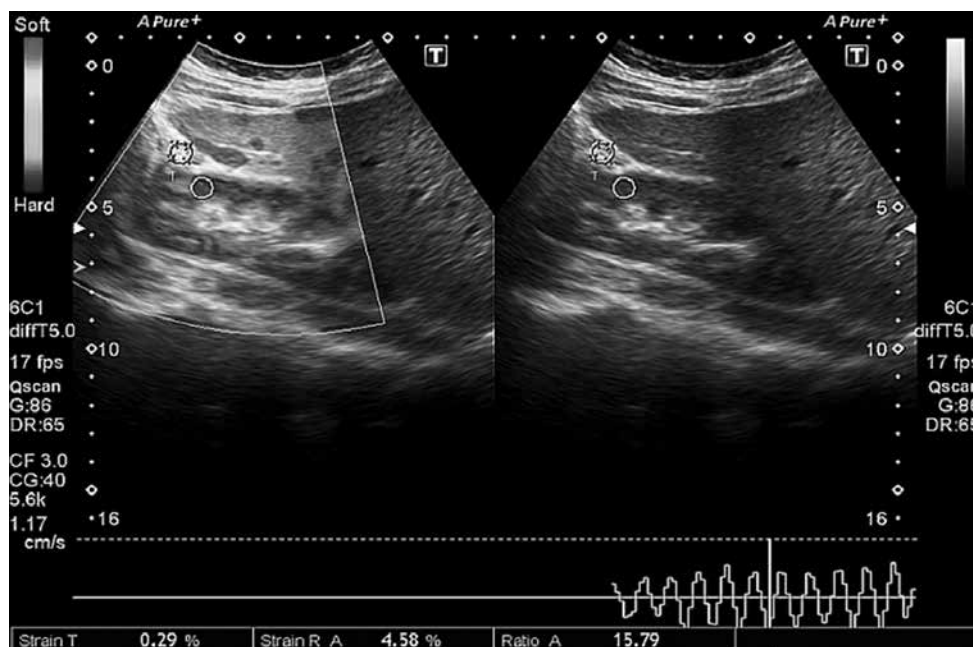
Strain elastography image of the kidney parenchyma. The image shows active elastography mode of ultrasonography (USG). The screen was divided into three parts as right, left and bottom. The color coded left side indicates elastography mode, while the right side is gray scale B-mode USG image. The bottom indicates the sinusoidal wave, which allows the operator to follow the compression and decompressions. The circles indicates the region of interests (ROI). One ROI was adjusted to the parenchyma while the other was in the perirenal fat tissue. The strain ratio was given below the screen.
